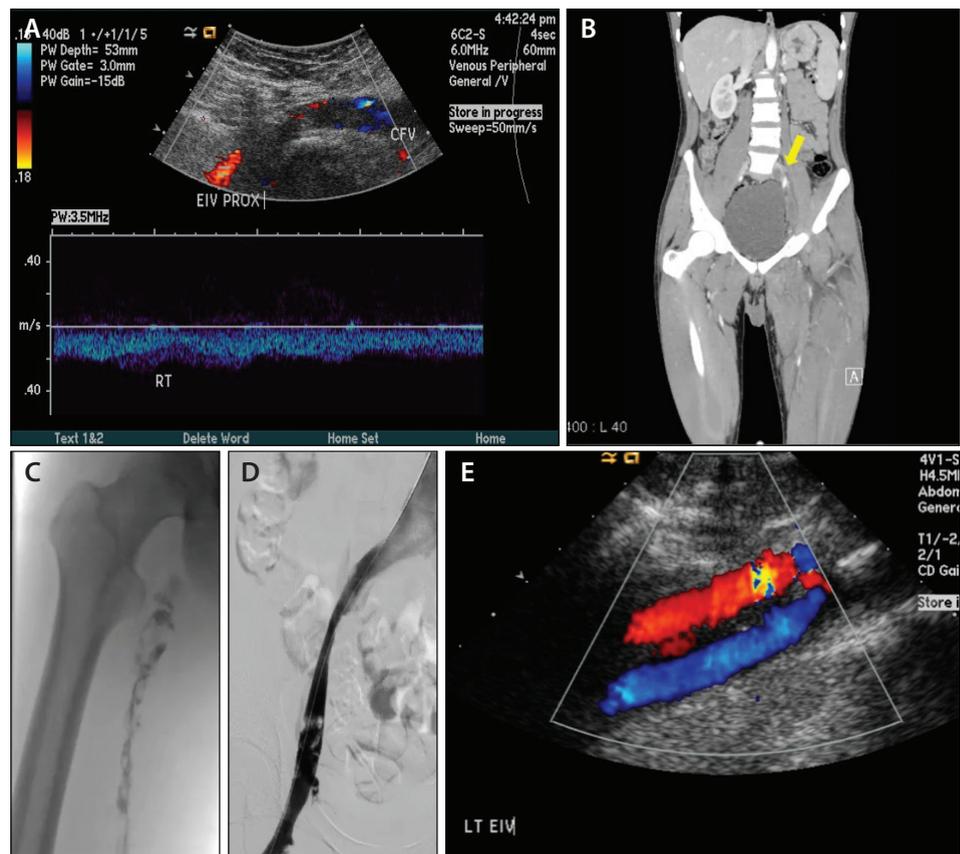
A 22-year-old athlete with factor V Leiden mutation and previous DVT. Ultrasound confirming external iliac DVT (A). CT confirming iliofemoral DVT (B). DSA angiogram demonstrating extensive clot in common femoral distribution (C). After AngioJet Power Pulse technique utilizing a Solent Omni catheter with 20 mg TPA and balloon venoplasty (D). Six-month follow-up ultrasound following anticoagulation with NOAC demonstrating patency, with return to baseline function (E).
